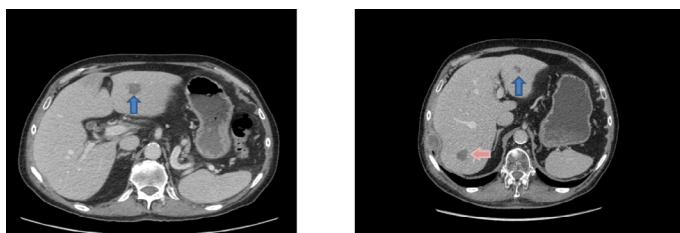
CT images of liver metastases at baseline and at 7 months (1 month after ended avelumab treatment). There is a significant reduction of in size of the liver metastases in segment 3 (blue arrows), but appearance of a new liver lesion (red arrow) indicate progression of disease at 7 months.
